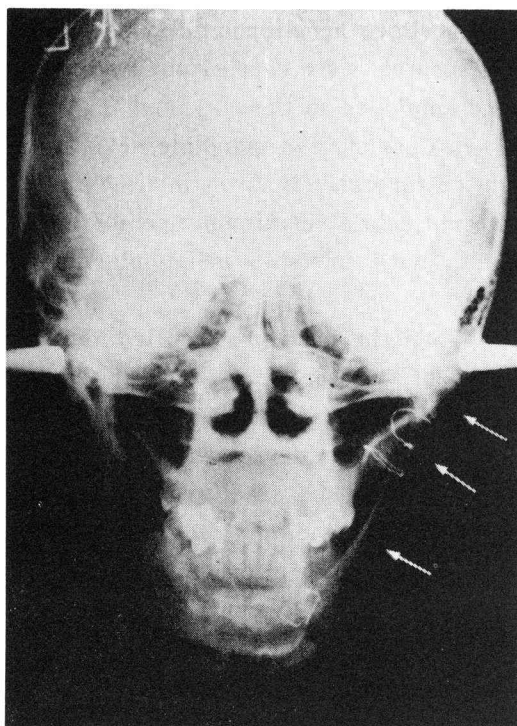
Postanterior radiograph the second year after bone regrafting of Case 2. The upper, middle and lower arrows show the condyle, primary iliac bone graft and secondary rib bone graft, respectively.
